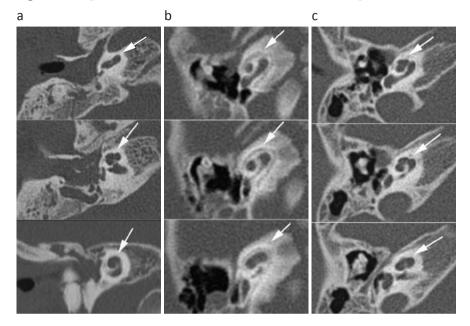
Range of abnormalities of the cochlea seen in axial CT images
